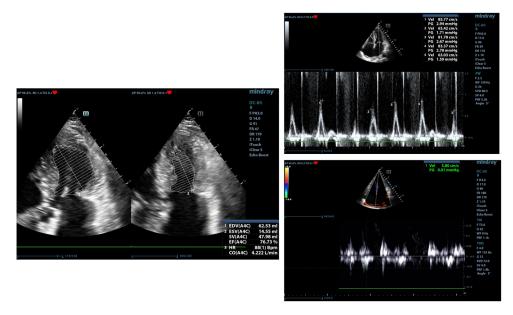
b.7. Left: supranormal LV systolic function (76%) and normal to small LV volumes (LVEDV=62 ml; LVESV=14 ml) (2D, 4-chambers view); Right: diastolic dysfunction in case presented (average E=75 cm/s, average  $e_s=5$ ; E/E'=15) (CW and tissue Doppler, 4-chambers view).
